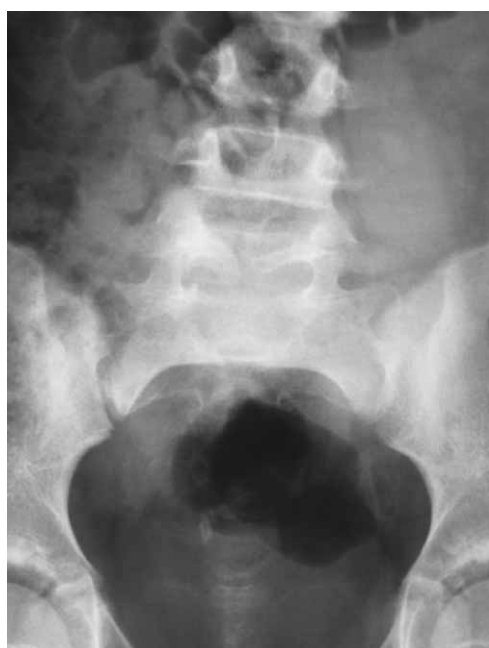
Standard radiographs of L-S junction in AP projection: Spina bifida occulta of L5 vertebra. Patient K.M., 8 years (girl).
